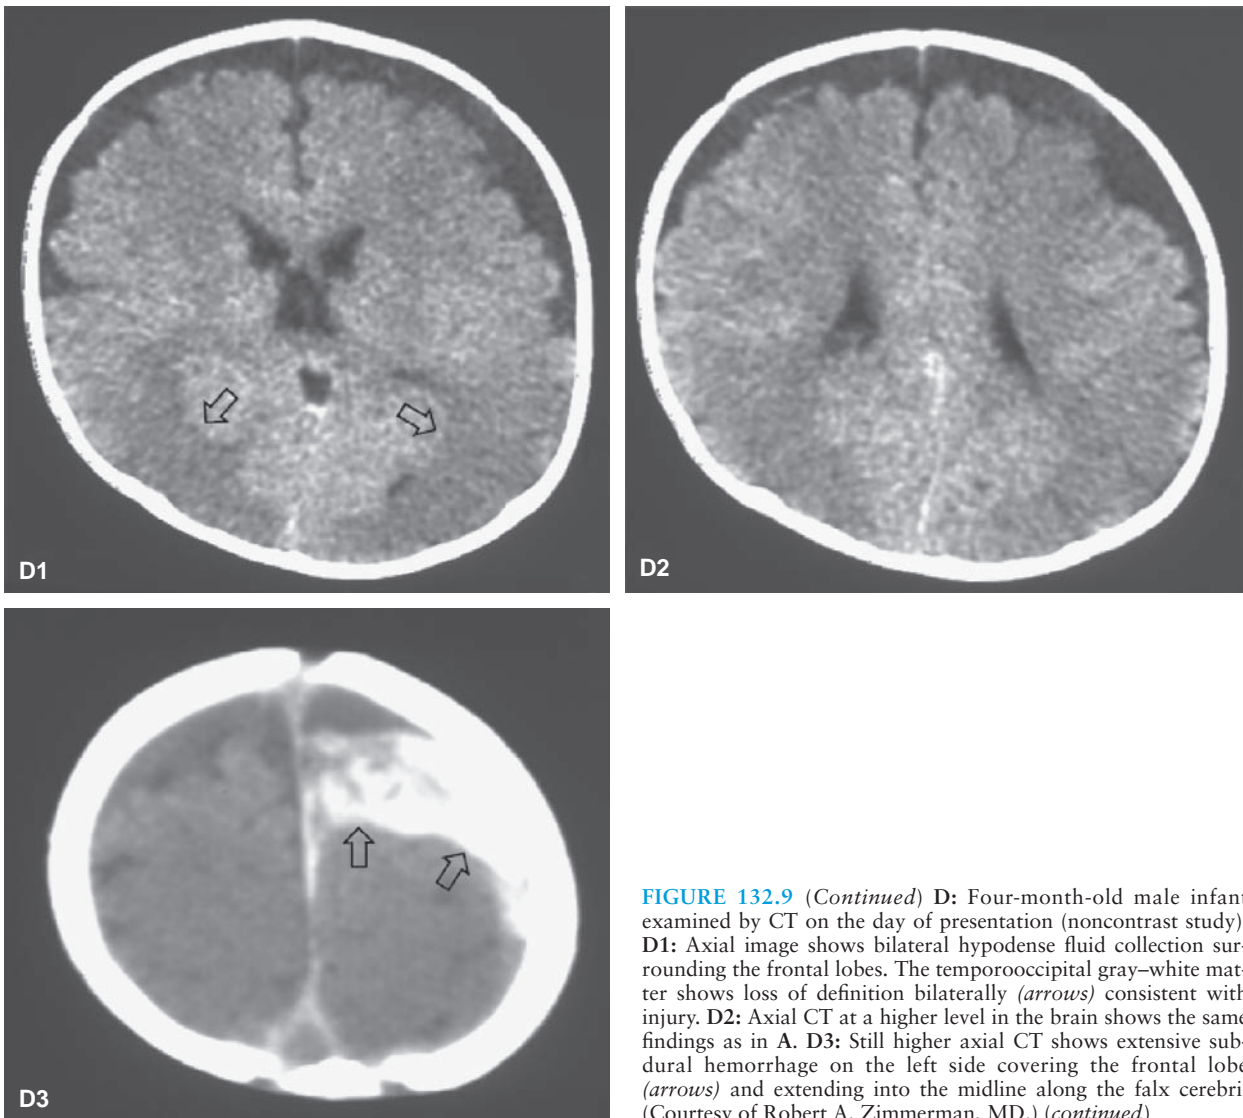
(Continued) D: Four-month-old male infant examined by CT on the day of presentation (noncontrast study). D1: Axial image shows bilateral hypodense fluid collection surrounding the frontal lobes. The temporooccipital gray–white matter shows loss of definition bilaterally (arrows) consistent with injury. D2: Axial CT at a higher level in the brain shows the same findings as in A. D3: Still higher axial CT shows extensive subdural hemorrhage on the left side covering the frontal lobe (arrows) and extending into the midline along the falx cerebri. (Courtesy of Robert A. Zimmerman, MD.) (continued)
